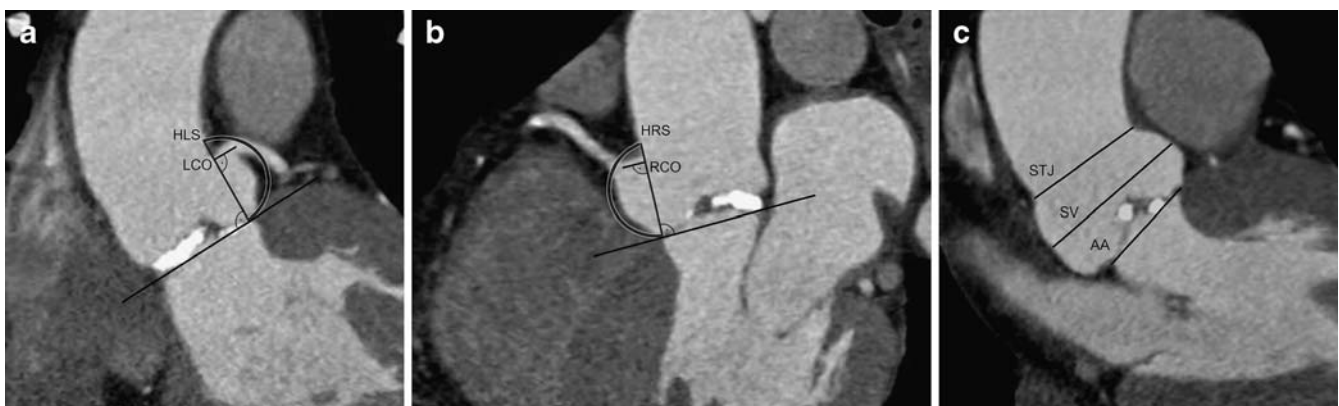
Measurements of coronary ostial locations and sinus heights with CT. Coronary ostial locations of the *LCO* were located on an oblique coronal reformation (a) orientated orthogonally to the plane of AA. *LCO* measurements were made from the base of the AA perpendicularly up to the center of the coronary ostium. Measurements for the left sinus height (*HLS*) were obtained by moving
